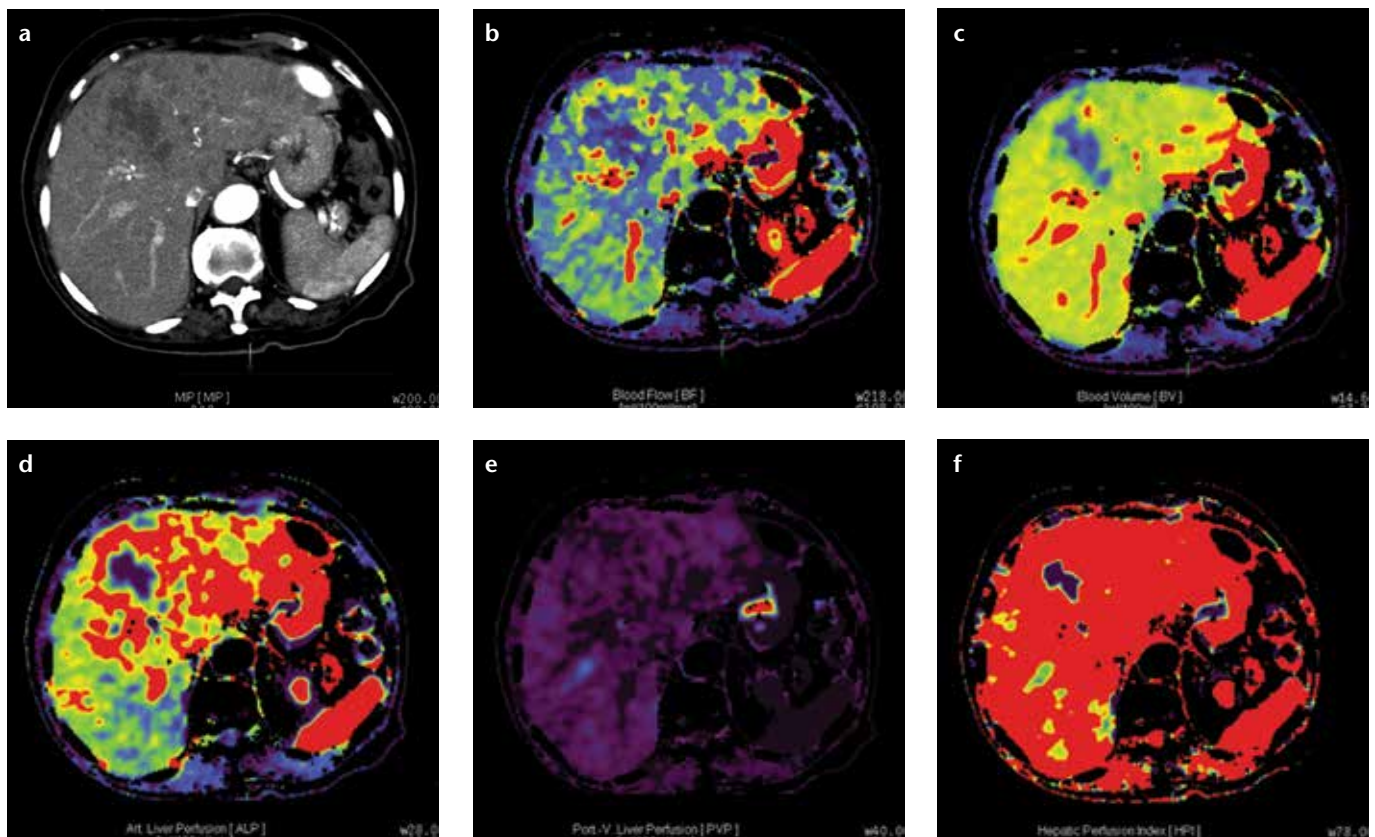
a–f. Axial perfusion images (a) and functional CT perfusion map (b–f) of a 45-year-old man with cholangiocarcinoma. The tumor shows an increased hepatic arterial perfusion and decreased portal perfusion compared with the normal parenchyma.
